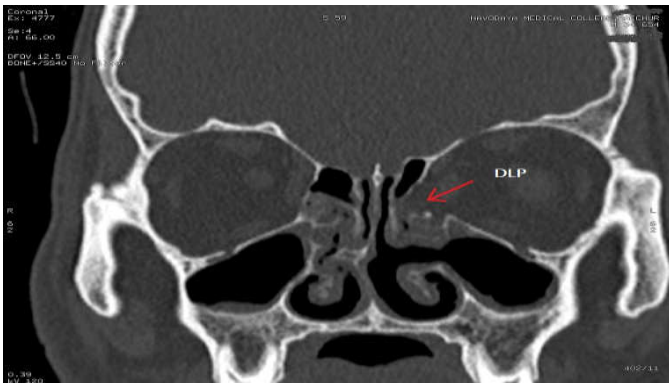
Coronal CT image show focal dehiscence of the left lamina papyracea (red arrow) with focal herniation of orbital fat into ethmoid sinus.
